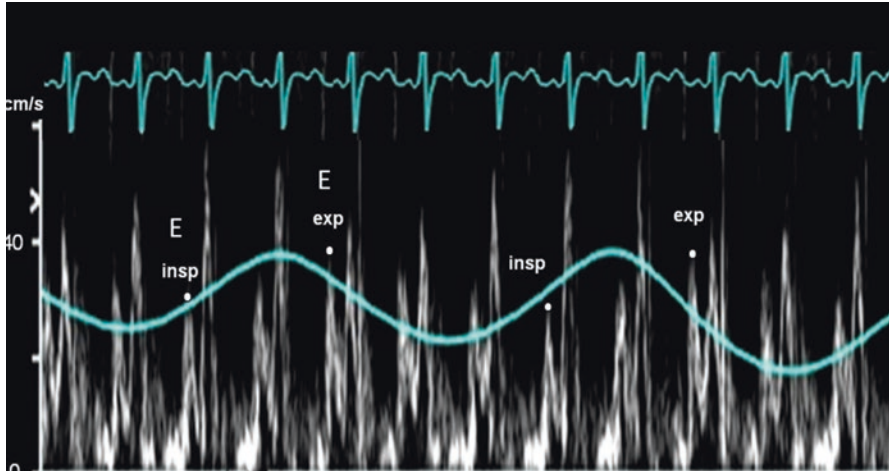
Pulsed-wave Doppler recording of mitral inflow with a respirometer in a patient with cardiac tamponade. There are low peak velocities and velocity-time integrals demonstrating reduced cardiac output. The peak E-wave inflow velocity (E) shows increased respiratory variation with the lowest values during the first beat of inspiration (insp) and the highest values on the first beat of expiration (exp) [% respiratory variation = $(\text{exp} - \text{insp})/(\text{exp})$]. In tamponade, the decrease in peak mitral E-wave velocity between expiration and inspiration is $>30\%$. Reproduced with permission from [5]
